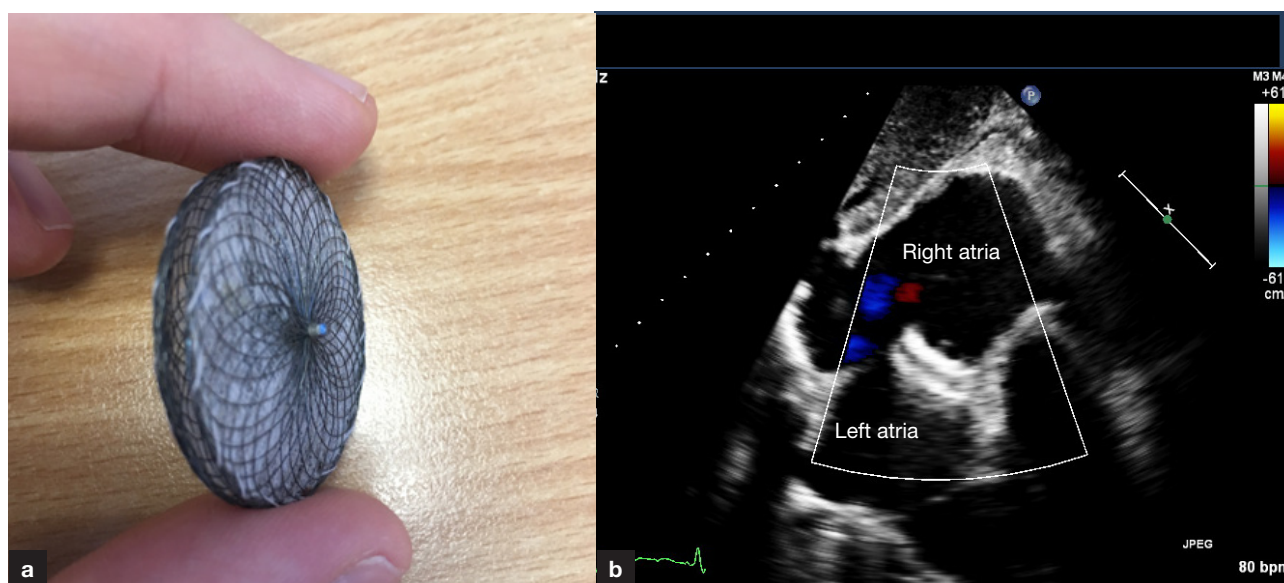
a. A percutaneous atrial septal defect occlude device ex-vivo with (b) a corresponding parasternal short-axis echocardiogram with the device seen in-situ between the atria at the 10 o'clock position.
